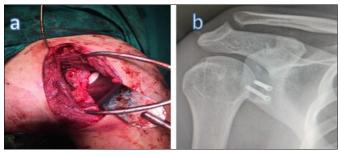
(a) Final coracoid fixation to the glenoid with its conjoined tendon exiting through the SS split; (b) Post-operative x-ray following Latarjet procedure.
